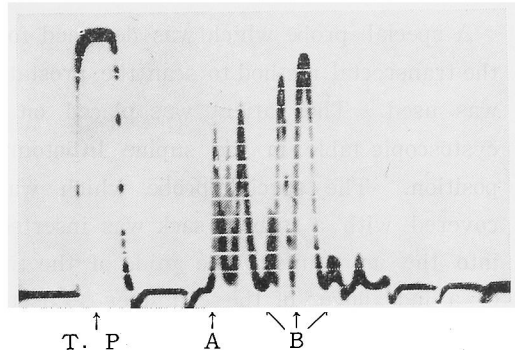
Ultrasono-echogram of Prostatic Stones.
